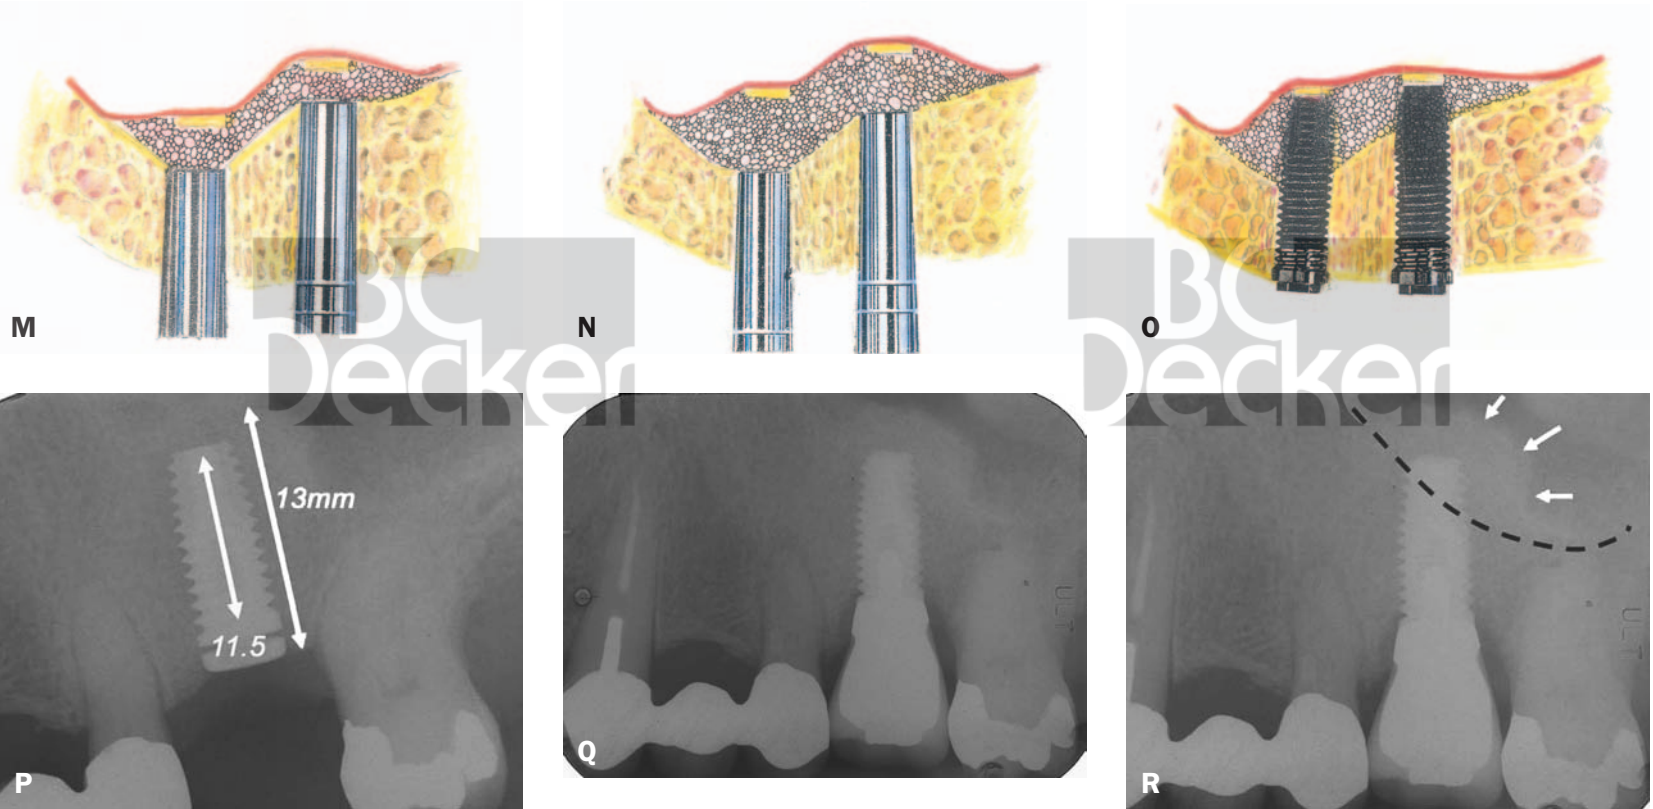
Continued. M and N, Additional material is added until the sinus floor is elevated to an appropriate height. O, Implants are placed at the time of surgery. P, Radiograph showing implant placement. Q and R, Final radiographs 12 months later showing the completed case. Note significant augmentation of the sinus. Compare with B and D.
